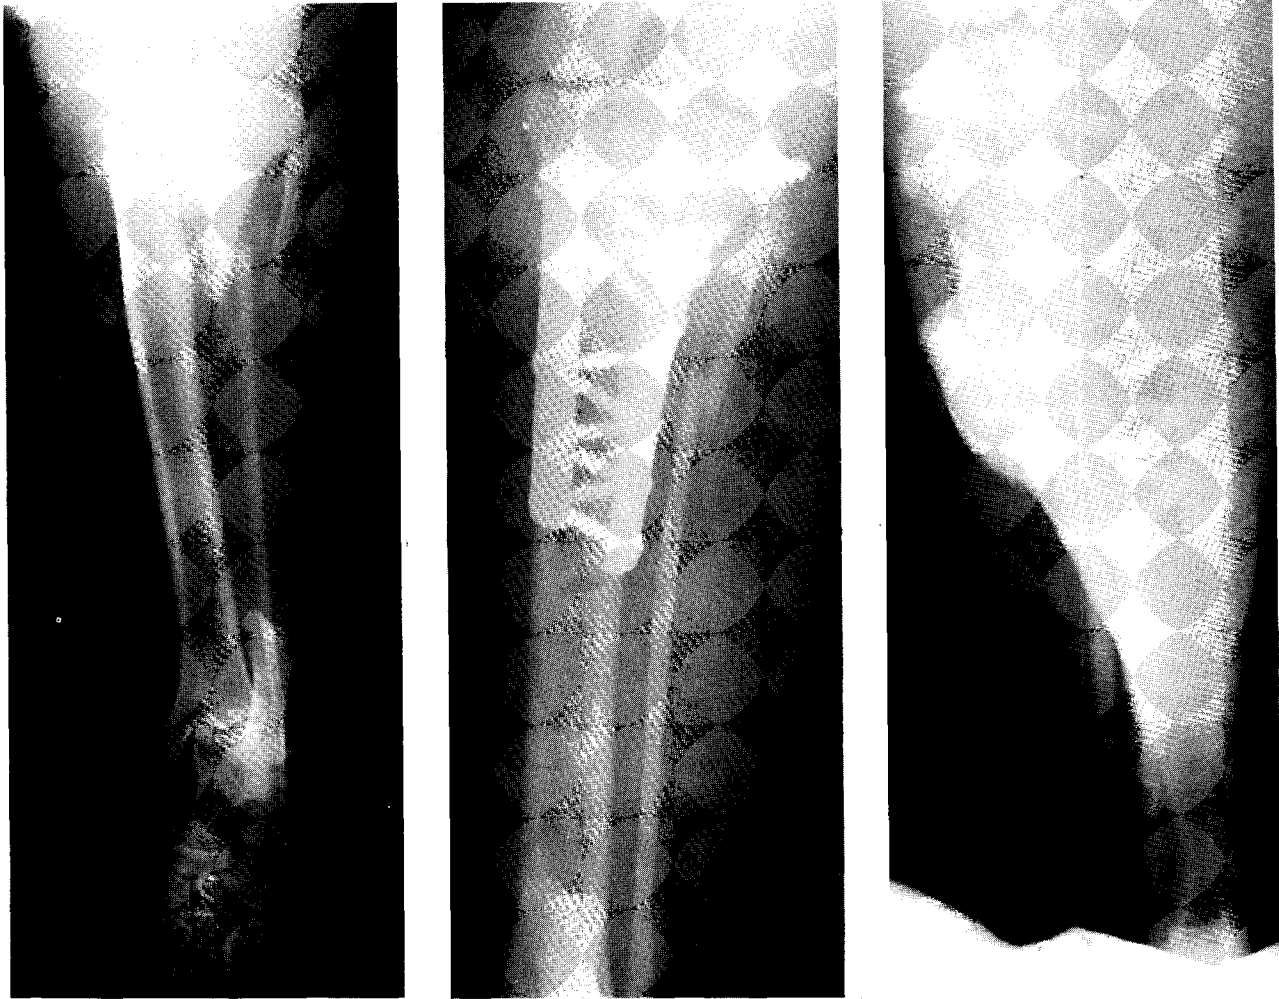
Anteroposterior radiograph of right fractured proximal tibia and fibula in an eight-month-old male African lion (*Panthera leo*). The fractured left tibia was similar.
